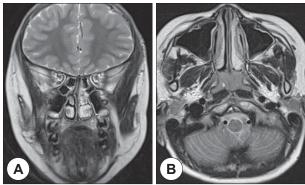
Follow up image of 8-year post operation. Temporal MRI of shows no recurrence or complication such as inflammation or deformity from defect(A: T2 weighted coronal view. B: T2 weighted axial view).
